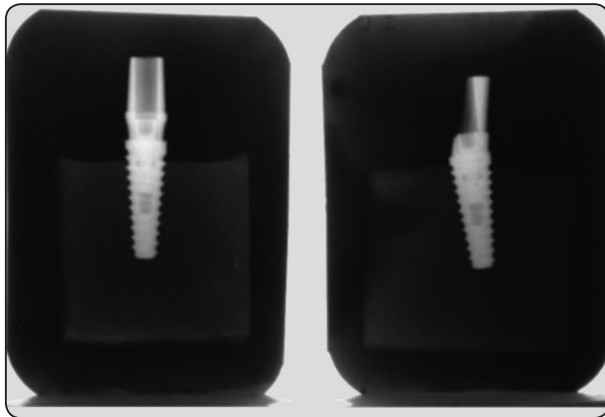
X-rays showing Platform-switched straight (left) and angled (right) abutments.
